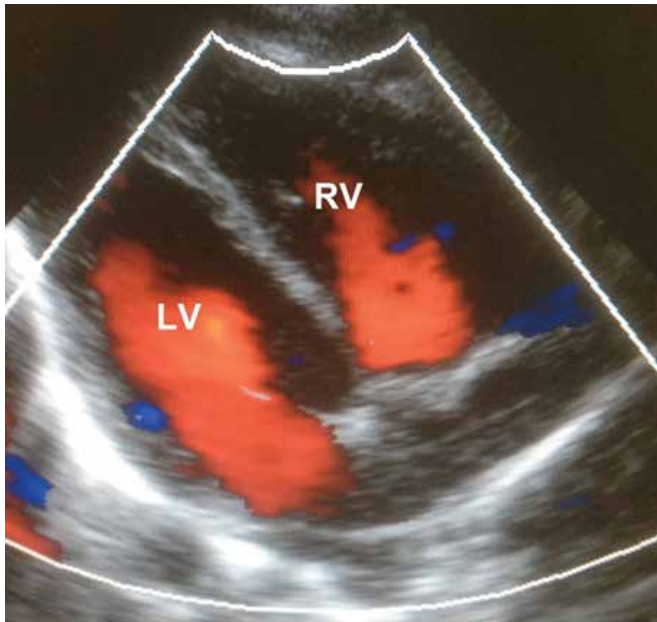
Ten weeks later, apical four-chamber view revealed the resolution of right ventricular hypertrophy with colour echocardiography. RV = right ventricle; LV = left ventricle.
